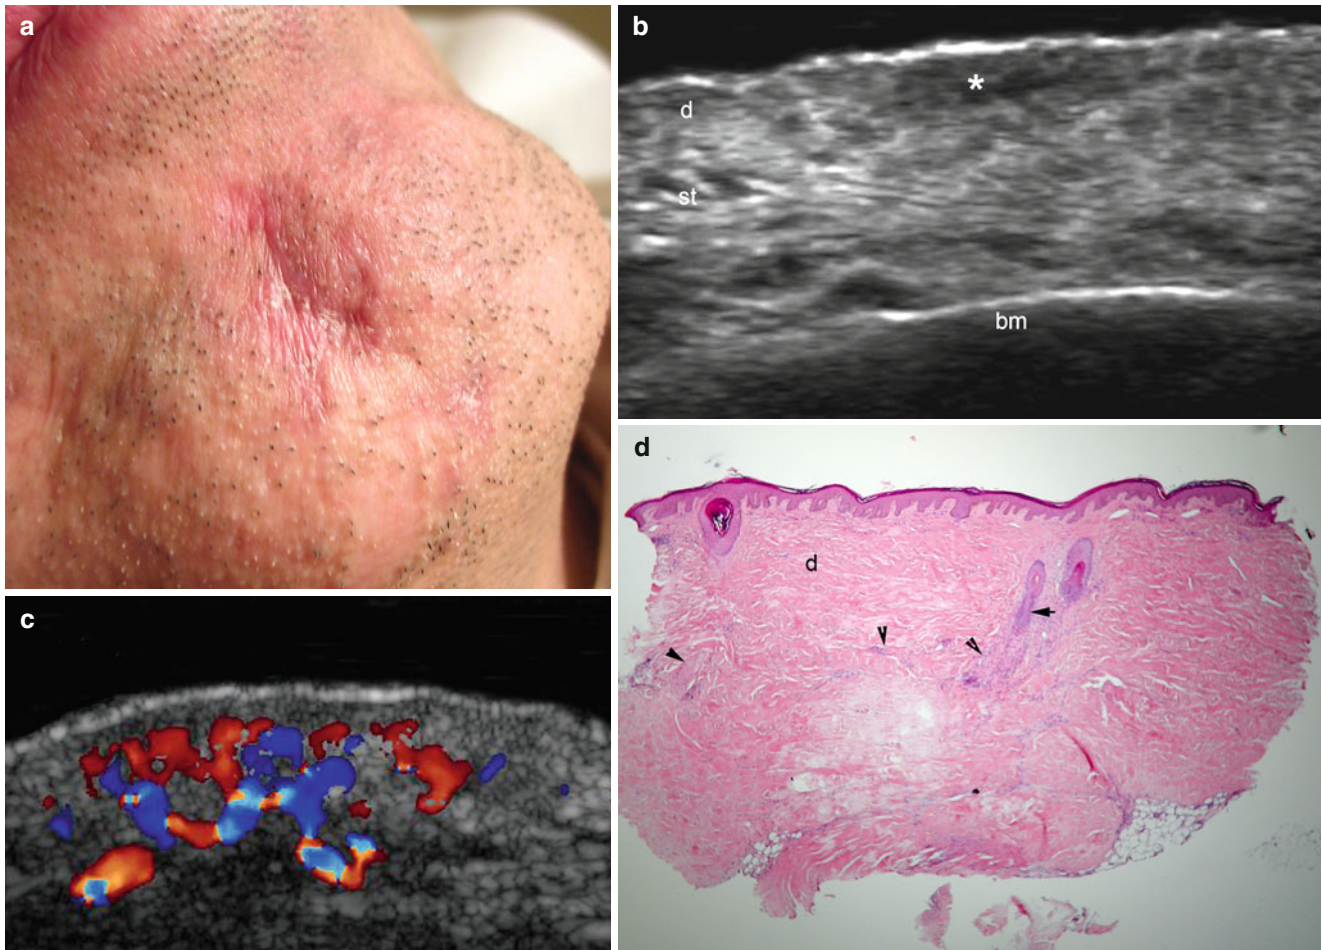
(a–d) Active morphea (inflammatory phase). (a) Clinical lesion shows erythema, swelling and retraction in the chin. (b) Gray scale ultrasound image (transverse view) demonstrates thickening and decreased echogenicity of the dermis (*) and increased echogenicity of the subcutaneous tissue. (c) Color Doppler ultrasound image (transverse view) shows increased vascularity in the dermis and upper
